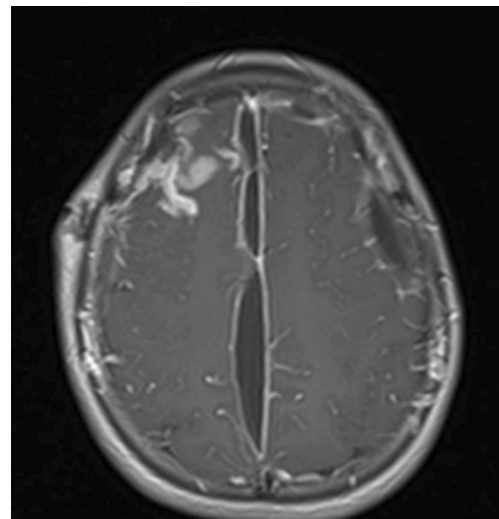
Axial T1-weighted MR image with gadolinium after the first right frontal burr hole, with disappearance of the right frontal subdural empyema and signs of adjoining cerebritis. Increase of the parafalcine collection is also evident
